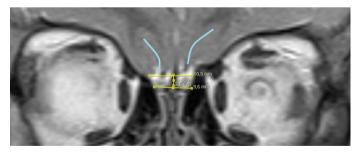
Coronal T2-weighted MR images show ethmoid roof height measurement was made from sections where the olfactory sulcus (blue lines) can be selected.
